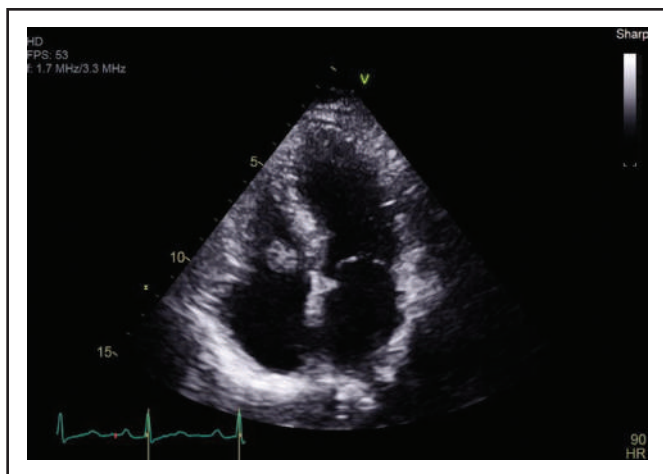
Apical four-chamber view demonstrating a mass on the tricuspid valve.
